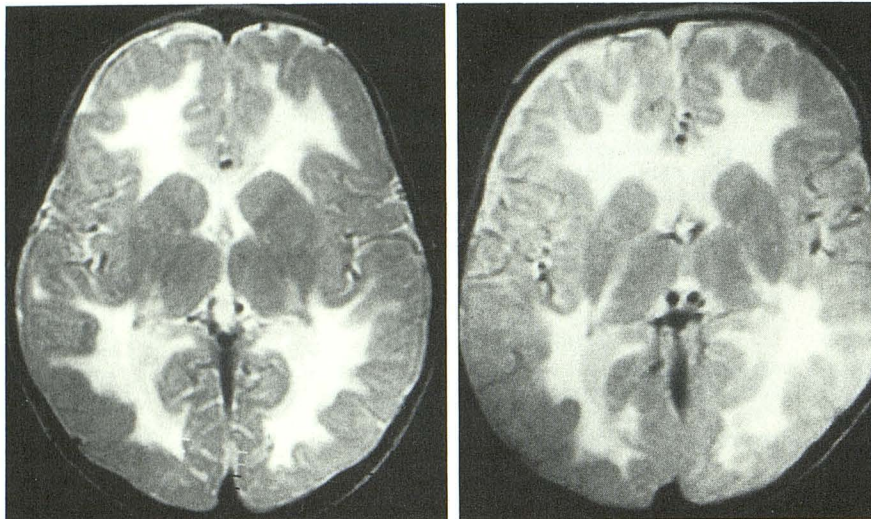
Case 5: 2-year-old mentally retarded girl with aspartoacylase deficiency, midline hypotonia, and brisk limb reflexes. No macrocephaly. MR image (2300/80) shows severe white-matter disease of subcortical white matter. Central white matter within internal and external capsules appears preserved, while myelination within genu of corpus callosum is abnormal. No gray-matter disease was seen. Posterior fossa white matter appeared normal.
